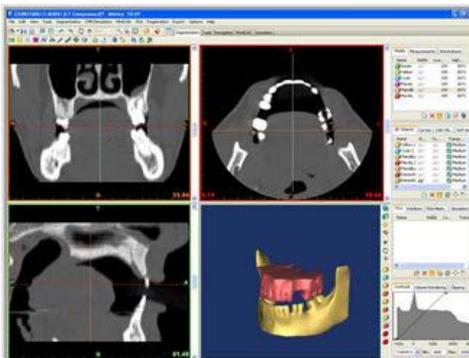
The 3D reconstruction using the CT scan
